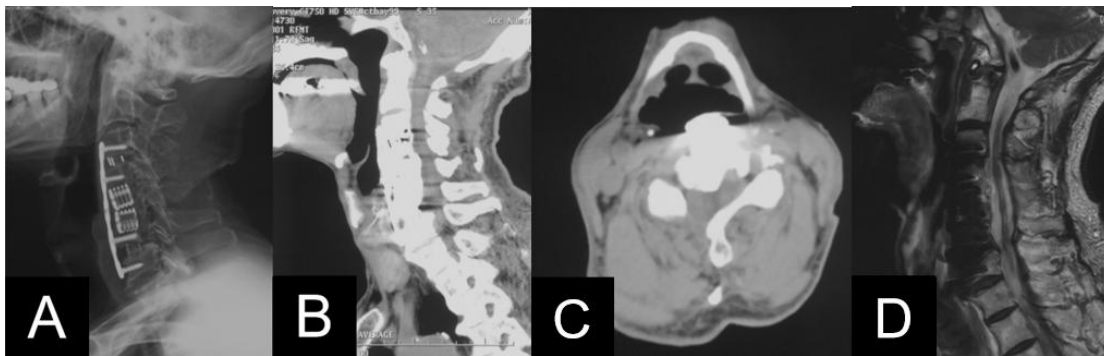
Long-term Follow-up Imaging: X-ray, CT, and MRI Evaluation 2 Years after ACAF
